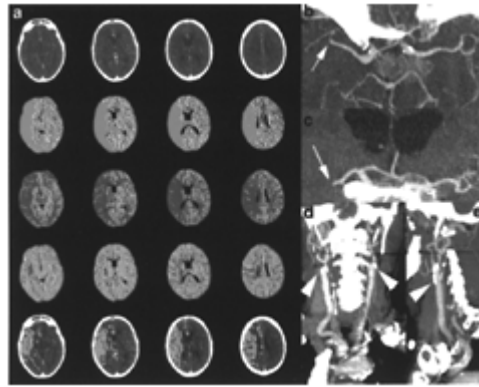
Modern CT survey in a 62-year-old male patient admitted in our emergency room with a left hemisindrome, including (a) perfusion CT and (b-e) CT angiography (CTA).
